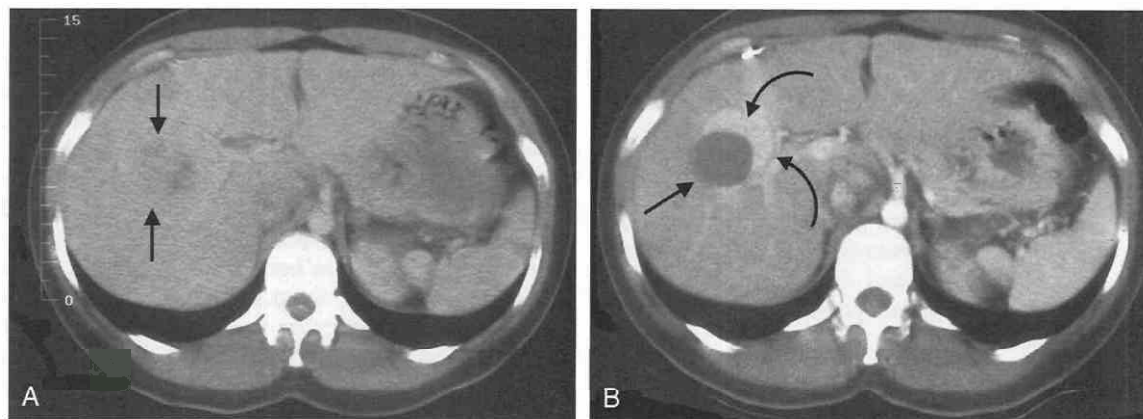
CT scan shows a large mass in the porta region of the liver (arrows). This was treated under MRI by radiofrequency treatment. B, Follow-up scan shows a low-density mass (arrow) representing the necrotic treated area. The large enhancing rim (curved arrows) represents recurrent tumor.
